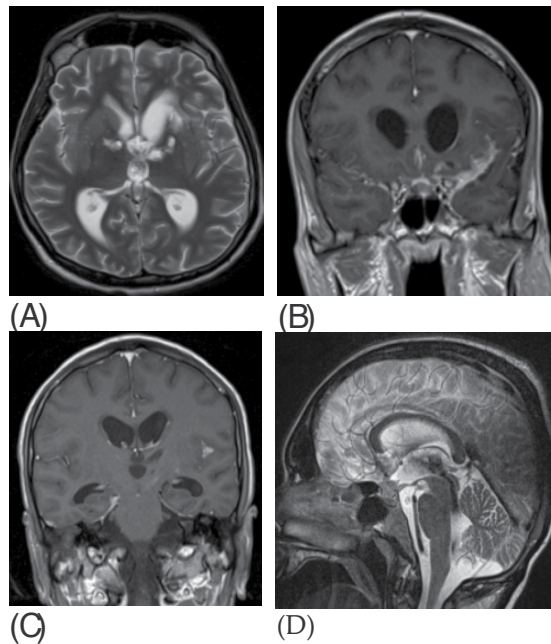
A-D. Cranio-cerebral MR: axial (A), coronal (B and C), and sagittal (D) images showing tuberculous meningitis, cerebral thrombosis and hydrocephalus in a 23-year-old patient with AIDS. He had been receiving antiretroviral treatment for 3 months prior to the present hospitalization. He was admitted with miliary TB and meningoencephalitis associated with oral HCV infection, candidiasis and reactivated CMV infection. The clinical evolution was complicated by toxic hepatitis due to antituberculous treatment and cerebral thrombosis. On admission the CD4 count was $244/\text{mm}^3$ and the RNA HIV load was 239 copies/ml. Contrast MRI before and after the administration of intravenous gadolinium and angioMRI (sag 3D PC phlebography) show: hyperintense lesions on FLAIR sequences and T2 weighted images, appearing hypointense on T1 with no contrast enhancement, located in the medial part of the lentiform nucleus and the head of the caudate nucleus; contrast filling of the basal cisterns extending to the sylvian fissure (more prominent on the left side), the floor of the third ventricle and the infundibular area (involving the optic nerves, chiasm and optic tracts); asymmetric profound venous system with bilateral amputation of the superior talamosriate veins without the visualisation of the anterior left vein of the pellucid septum; enlargement of the ventricular system with no median shift or transependimar resorption. *Conclusions:* post ischemic sequelae, thrombosis of the profound venous system, basal meningeal contrast enhancement suggestive for meningitis and dilation of the ventricular system.
